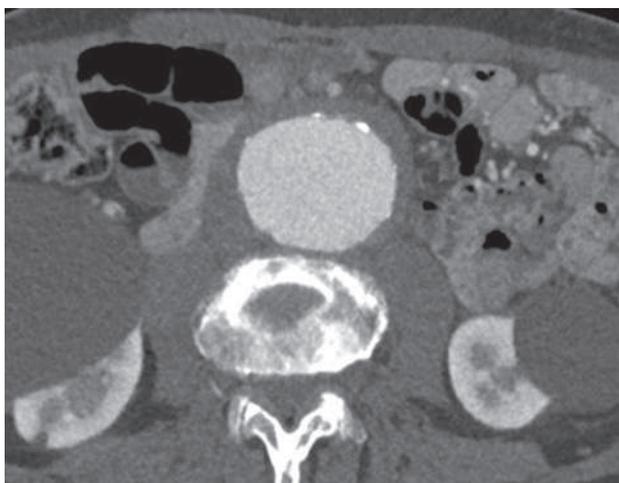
Axial computed tomography angiography (CTA) image demonstrating the characteristic circumferential peri-aortic inflammatory rind surrounding the aneurysm, typically appearing as a high attenuation, soft tissue mantle (artist and copyright Carlota F. Prendes, Uppsala, Sweden).
